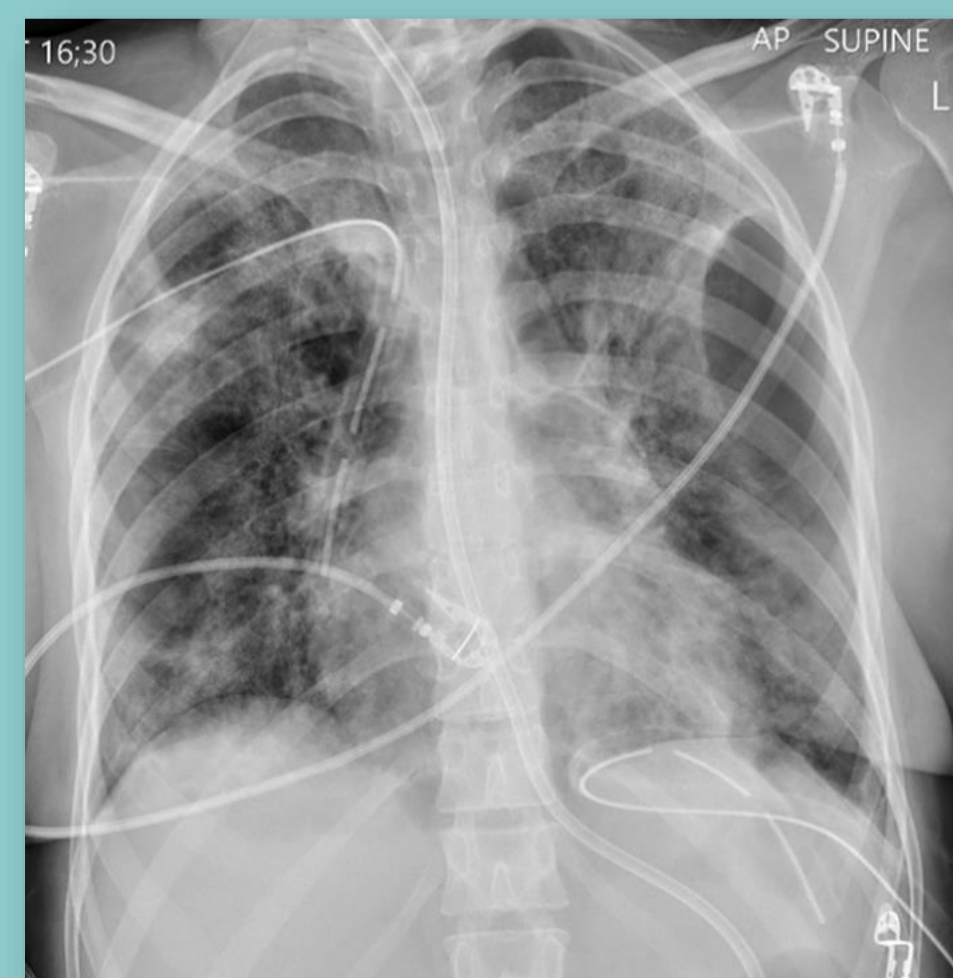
Admission Chest X-ray
